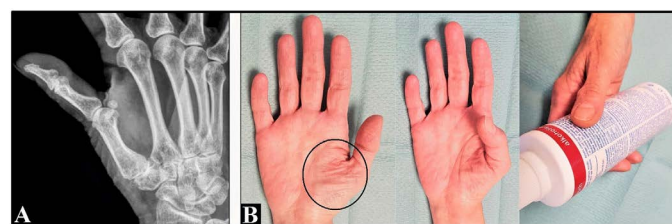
(Case presentation). (A) Preoperative radiograph showing the advanced stage of right CMCJ I OA. (B) Preoperative clinical photographs showing the pronounced thenar muscle atrophy (circle) resulting in an insufficient abduction/opposition/circumduction of the thumb with an incomplete object grasp
